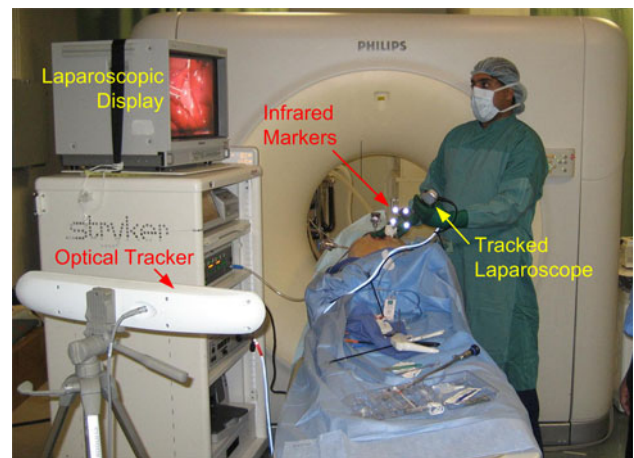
Typical experimental setup for continuous computed tomography (CT)-based laparoscopic surgery with live augmented reality (AR) visualization. The major equipment includes a CT scanner, a laparoscopic imaging system, and an optical tracker for tracking the laparoscope in CT coordinates
